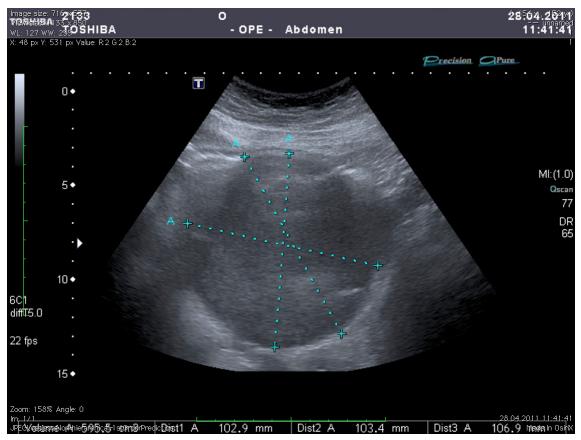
Ultrasound examination of the stomach presenting liquid-filled balloon properly placed with no residual air.
